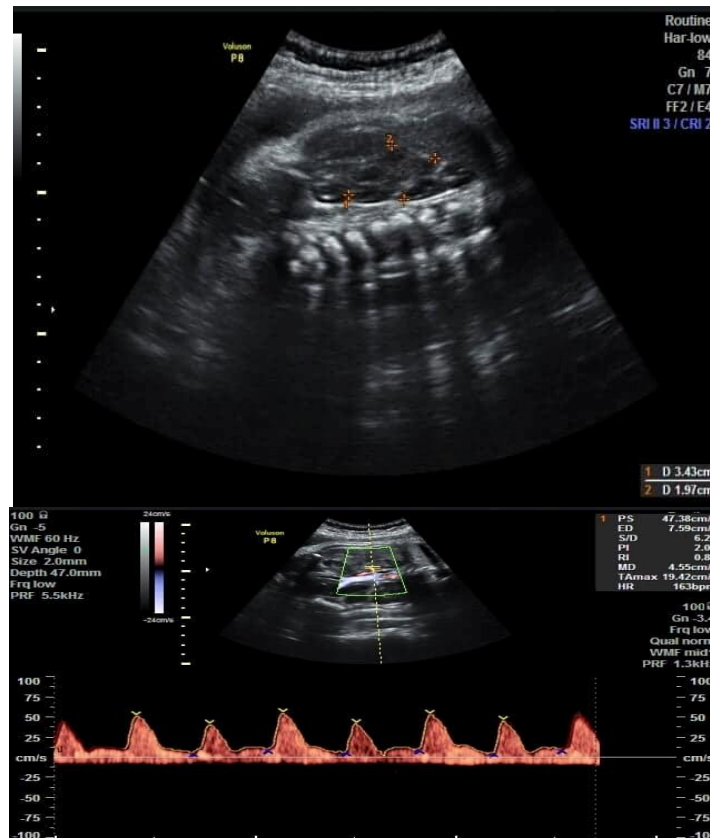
Ultrasound of normal fetus aged 34 weeks show normal renal measurements and normal renal Doppler
